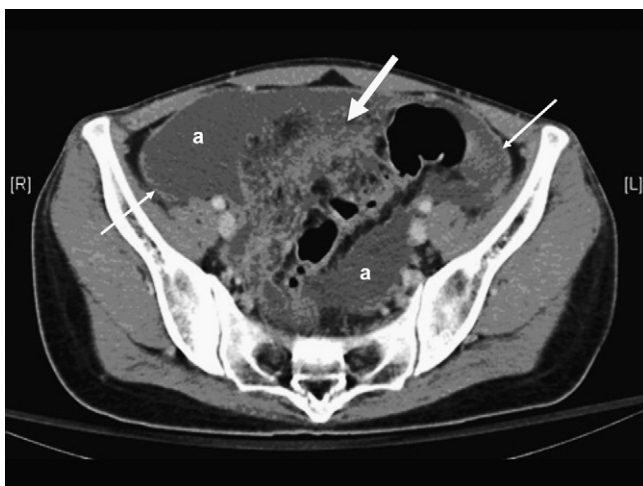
Computed tomographic image of a patient revealing moderate and separated ascites with a thickened mesentery and peritoneum lining (small arrows), prominent strands in the omentum, and a sigmoid mesocolon (large arrow). a = ascites.
